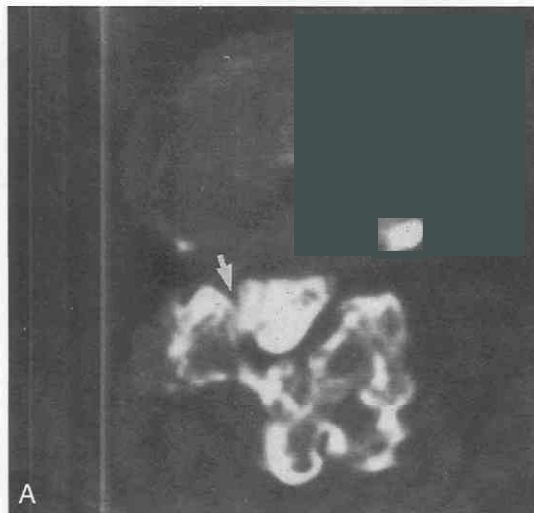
A, Facet hypertrophy. Postmyelogram CT scans shows massive facet hypertrophy bilaterally. Arrow indicates facet encroachment on the thecal sac. Compare with normal facets in Figure 22-4G. B, T2-weighted MR image shows hypertrophied facets (f) and ligamentum flavum (l) encroaching on the foramina, (arrows), obliterating the foraminal fat and severely narrowing the canal (c). C, T2-weighted MR image shows asymmetrical facet hypertrophy. The left facet exerts mass effect on the canal (black arrow). Compare with normal facets in Figures 22-3B and 22-4C and D.
